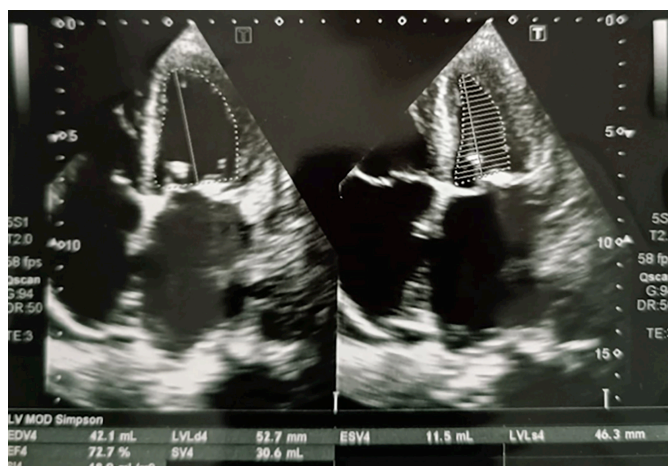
Echocardiography of the presented patient.
